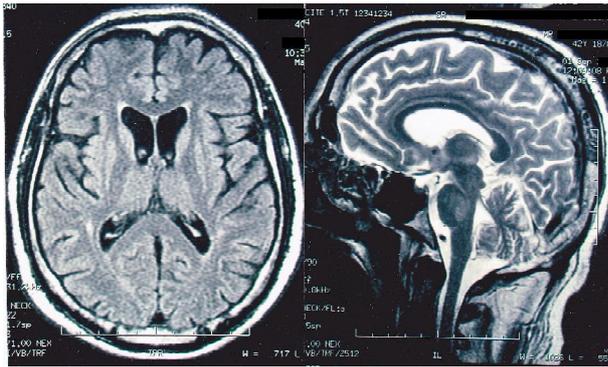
Follow up MRI at 8 weeks showing resolution of the abnormalities seen in Figure 1.
